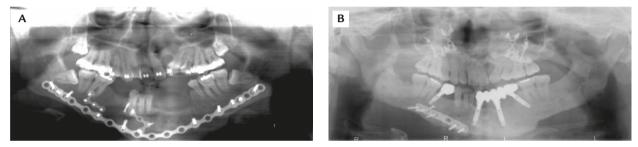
Radiographical images at different phases of treatment. (A) Panoramic radiograph after emergent open reduction surgery. A long titanium reconstructive plate was used to immobilize and maintain the continuity of the fractured mandible. (B) Panoramic radiograph after comprehensive and didactic surgical procedures. Miniplates with screws for LeFort I osteotomy, a compression plate with screws for the bone graft of the mandible and prostheses supported by 4 implant fixtures are shown.
